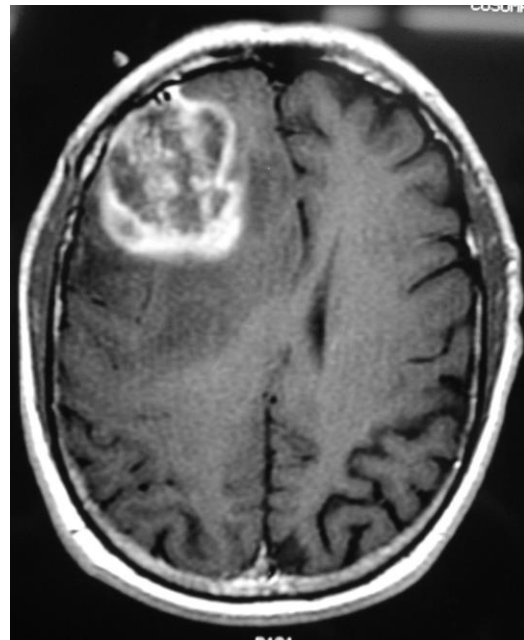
MRI of glioblastoma multiforme (GBM)
